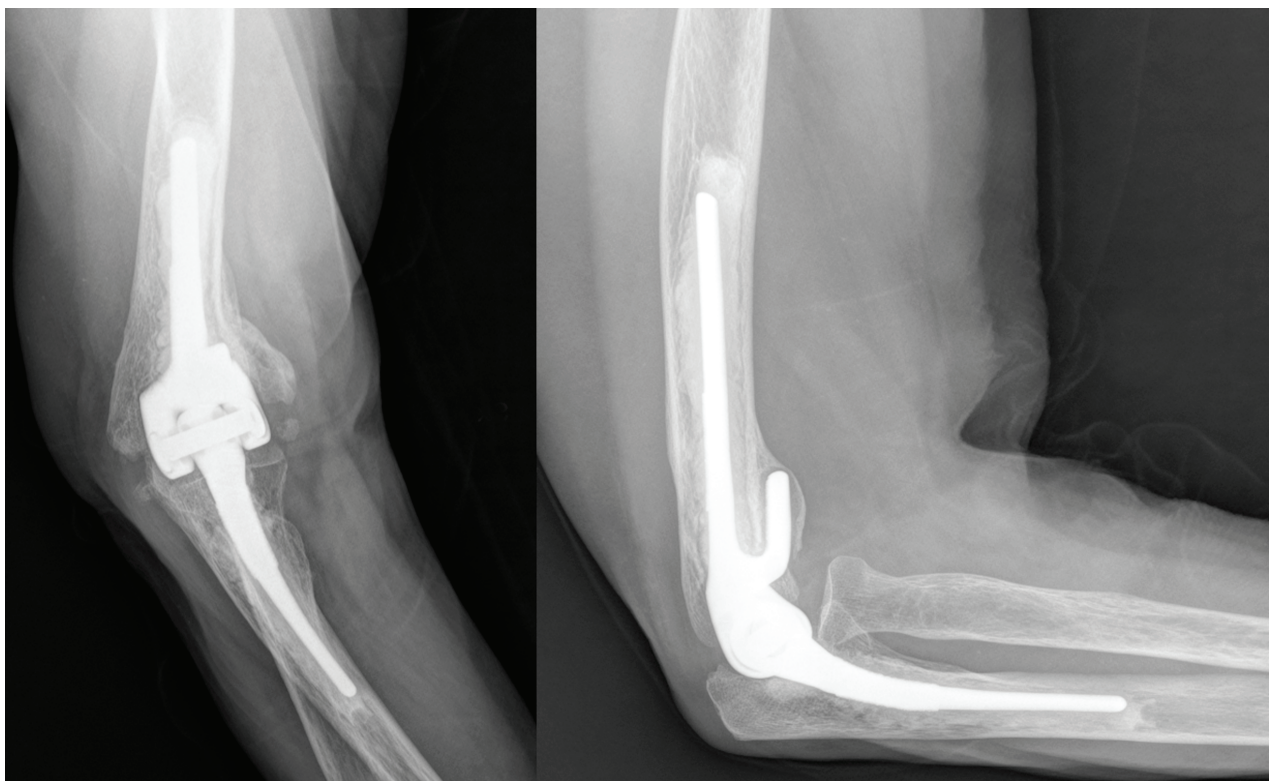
X-rays at 3 years follow-up; grade 2 LE-Morrey criteria.
